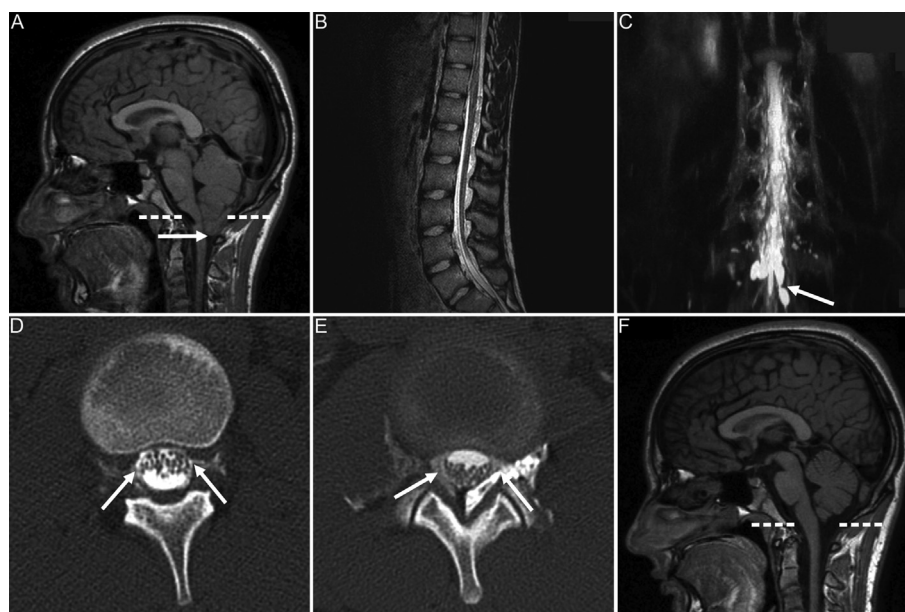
(A) Sagittal T1-weighted MRI 6 months after the onset of headaches, showing 11 mm prolapse of the cerebellar tonsils (arrow) into the foramen magnum (dashed line), narrow ventricles and enlarged cerebral veins. (B) Sagittal T2-weighted MRI, showing a narrow spinal canal. (C) Coronal 3D-CISS sequence, showing a CSF collection around the first sacral nerve roots, especially on the left side (arrow). (D) Axial CT myelography, showing extensive CSF leakage bilaterally (arrows). (E) Re-CT after application of epidural blood patch, showing that the patch (arrows) covers the whole circumference of the dural sac. (F) Sagittal T1-weighted MRI 2 months after the intervention, showing that findings normalized. Note in particular re-ascent of the cerebellar tonsils above the foramen magnum (dashed line).
